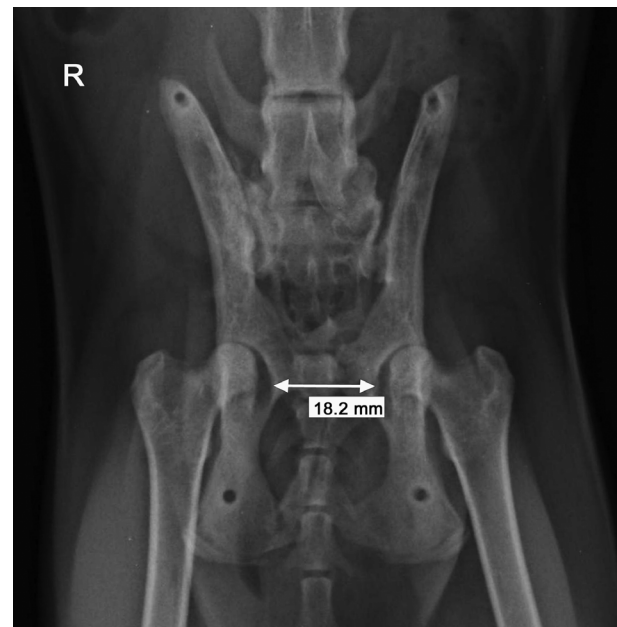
Ventrodorsal pelvic radiograph at the time of the implant removal, 45 days after the surgery
